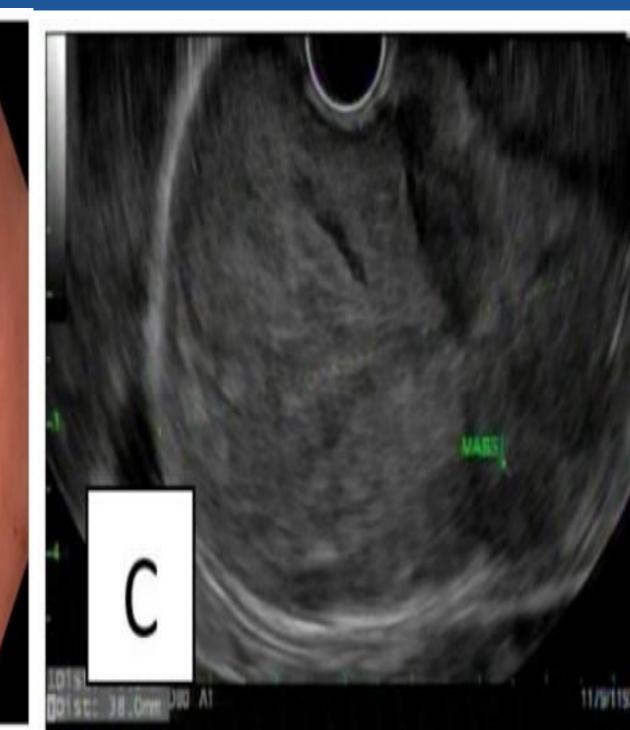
EGD findings consistent with a large, bilobed subepithelial mass measuring 10-15 cm with an area of ulceration within the mass (seen best on retroflexion) was found on the lesser curvature of the stomach along the anterior wall of the stomach. Figure 1C: Endoscopic US findings showed A 43.0 mm x 77.8 mm subepithelial lesion was found likely arising from the fundus, lesser curve and body of the stomach s/p FNB x 4. The lesion was hypoechoic and had some cystic spaces within it in some areas. Sonographically, the lesion appeared to originate from the stomach, but the wall layers could not be determined due to the large size of the mass.
